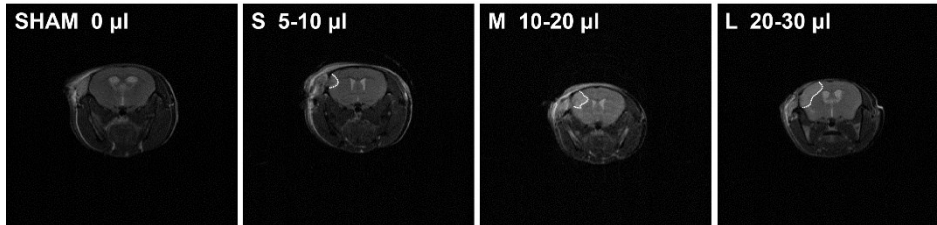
Representative magnetic resonance images of focal cerebral ischemia-induced lesion size. The lesion size classified by experienced operator during sample collection (S – small, M – medium, L – large) (Androvic et al., 2020).
